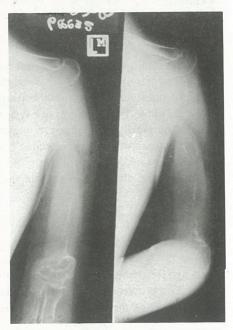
Follow-up radiographs 18 months from onset showing total humeral lysis with involvement of shoulder girdle and proximal ulna.
